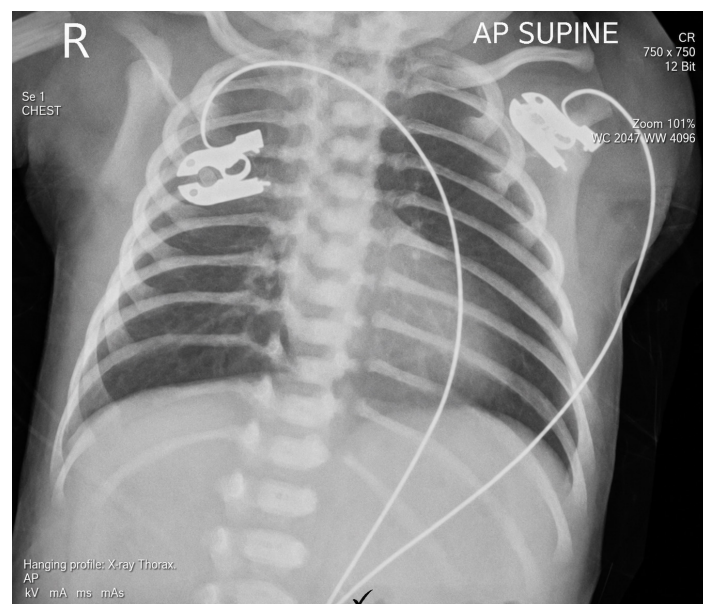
Chest X-ray in the emergency room showing a boot-shaped heart and pulmonary oligemia.
